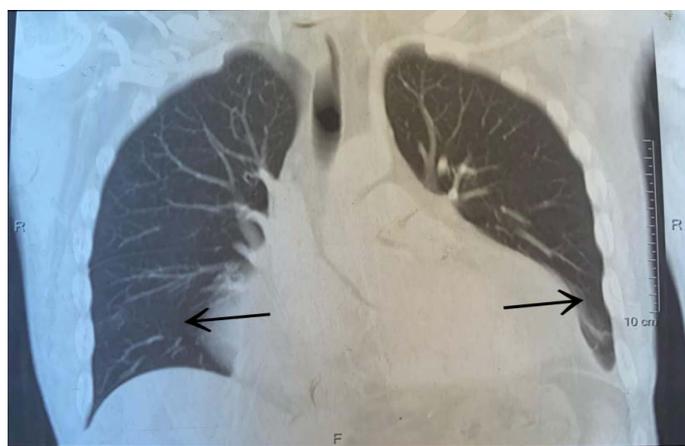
An enlarged fragment of the MS CT film of the chest organs of patient P., 42 years old, dated 07/16/2020, which clearly shows how the identified cystic formations created moderate compression of the adjacent parts of both lungs (shown by arrows).
